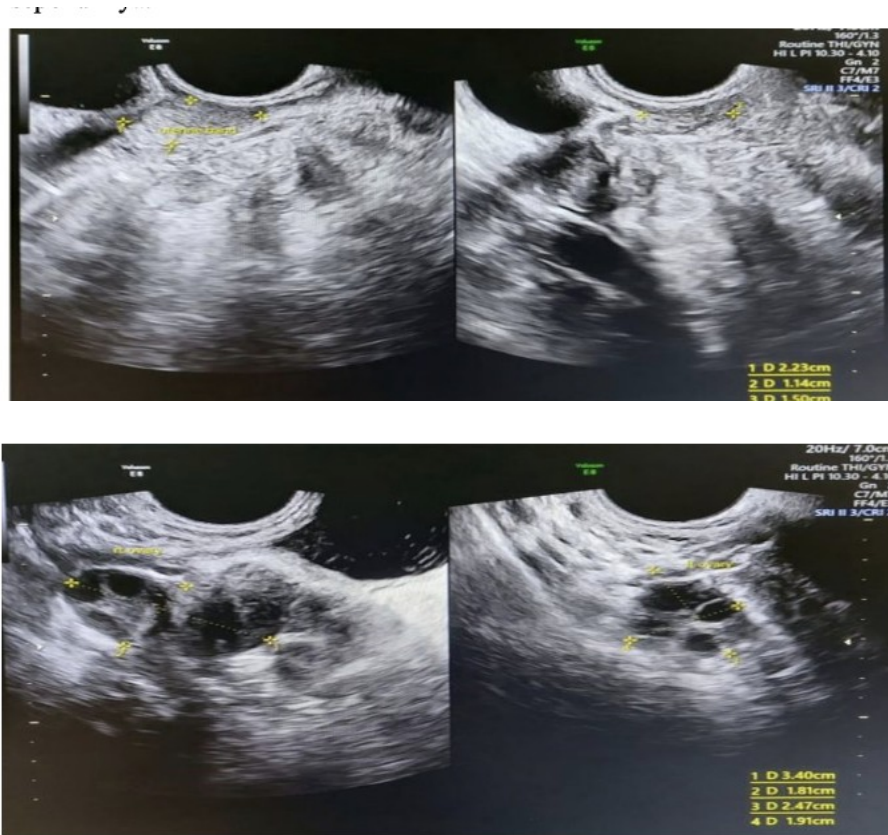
Ultrasound Examination Results
